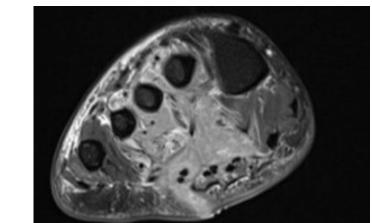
MRI demonstrating phlegmonous changes deep to the flexor tendons
